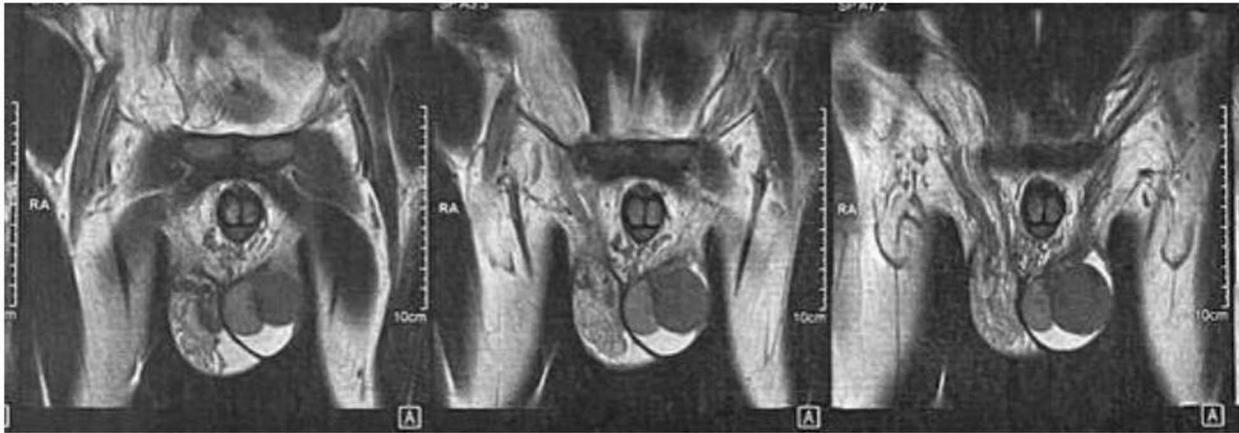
Pre-operative MRI showed the accessory testis in the upper hemiscrotal sac with mild homogenous enhancement.
